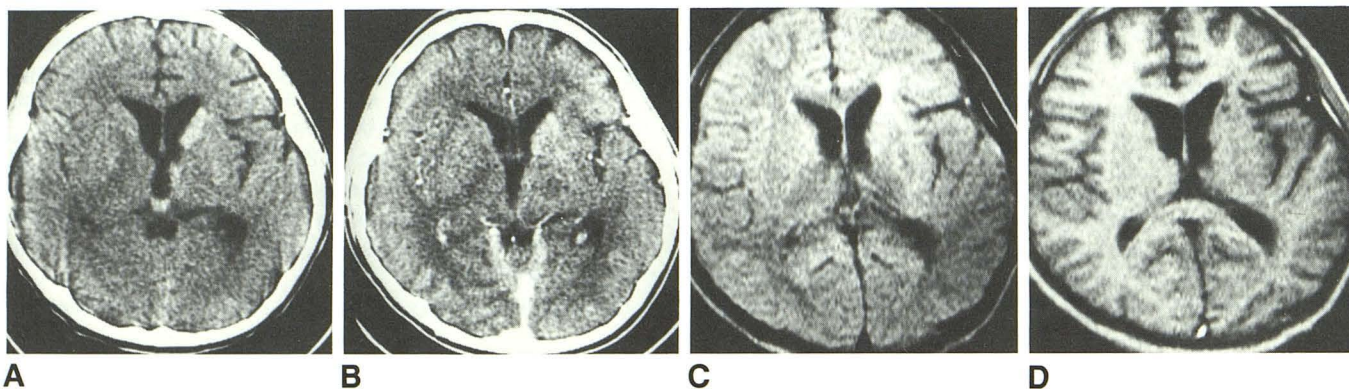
A, 13-year-old boy. CT shows high-density lesion in left basal ganglia with asymmetry of anterior horns of lateral ventricles.
